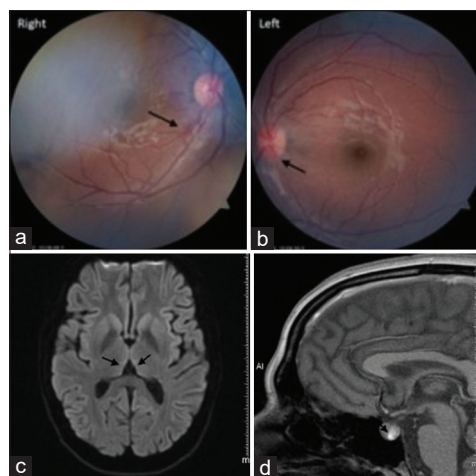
(a) Right fundus, superficial haemorrhage along the inferior temporal arcade. (b) Left fundus disc hyperaemic with mild oedema. (c) MRI Brain flair, medial thalamic hyperintensity, and (d) MRI Brain T1 shows haemorrhage into the posterior aspect of the anterior pituitary
